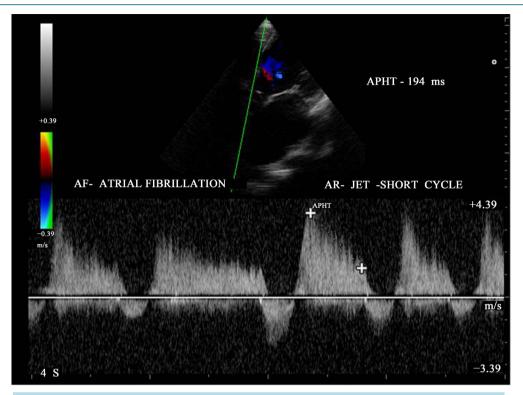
CW doppler imaging showing the AR jet-pressure half-time in short cycle in AF (atrial fibrillation)—steeper slope of pressure decay.
